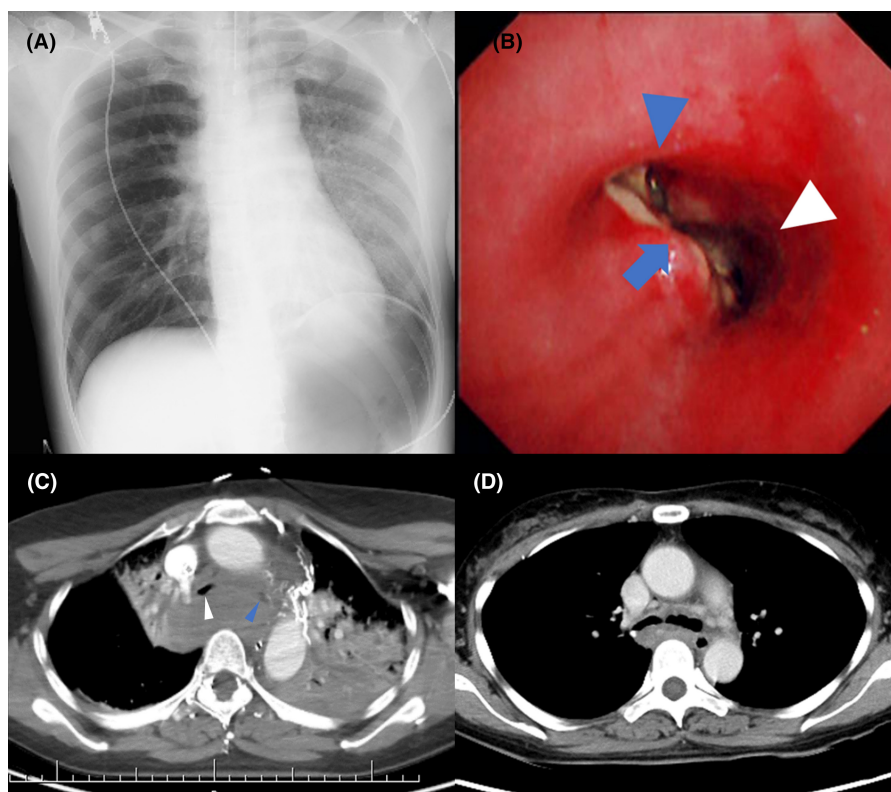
Chest radiography (A) does not clearly reveal any abnormalities at first glance. Although the carina appears indistinct, the positioning of the tip of the tracheal tube seems to be appropriate. However, closer inspection reveals a decrease in transparency of the left lung and a mild leftward mediastinal shift, suggestive of left lung atelectasis. Furthermore, there is an absence of the radiolucent image of the airways originating from the carinal bifurcation extending into both bronchi. Additionally, the left diaphragm is elevated. Bronchoscopic findings on the day of admission (B). Infiltration and compression of the carina (a blue arrow), right main bronchus (a white arrowhead), and left main bronchus (a blue arrowhead) by the lung tumor. We attempted to place an endobronchial stent falter owing to severe airway compression and infiltration. Chest computed tomography (CT) on the day of admission (C) shows a large mediastinal mass compressing the carina and both main stem bronchi. The tumor's compression and infiltration have rendered the carina indistinct. The right main bronchus (a white arrowhead) is significantly stenotic, and the left main bronchus (a blue arrowhead) is obstructed. Furthermore, a consolidation is observed in the dorsal region of the left lung caused by the obstruction of the left main bronchus. Subsequent CT following radiotherapy (D) showed a reduction in the tumor size, with decreased compression of the carina and both main stem bronchi.
